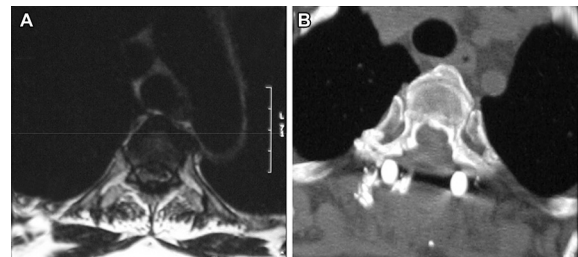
(A) Preoperative magnetic resonance imaging scan of T3–T4. (B) Postoperative computed tomography scan of T3–T4.
